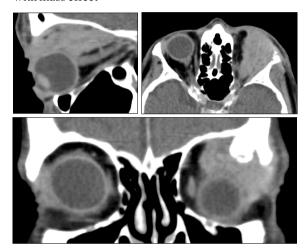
CT identifying biopsy proven epithelial
